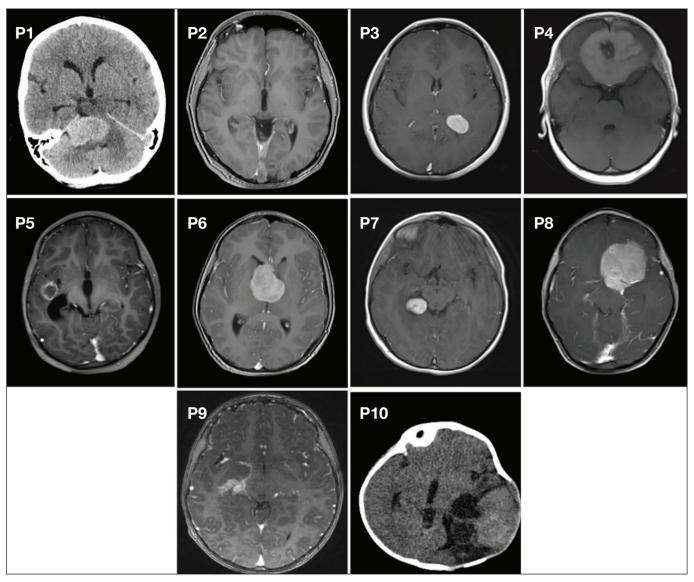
Axial T1-weighted contrast-enhanced MR and nonenhanced CT images taken pre- and postoperatively, shown by patient number (only brain CT was performed in patient numbers 1 and 10 preoperatively; because of this, nonenhanced CT images are included here).
